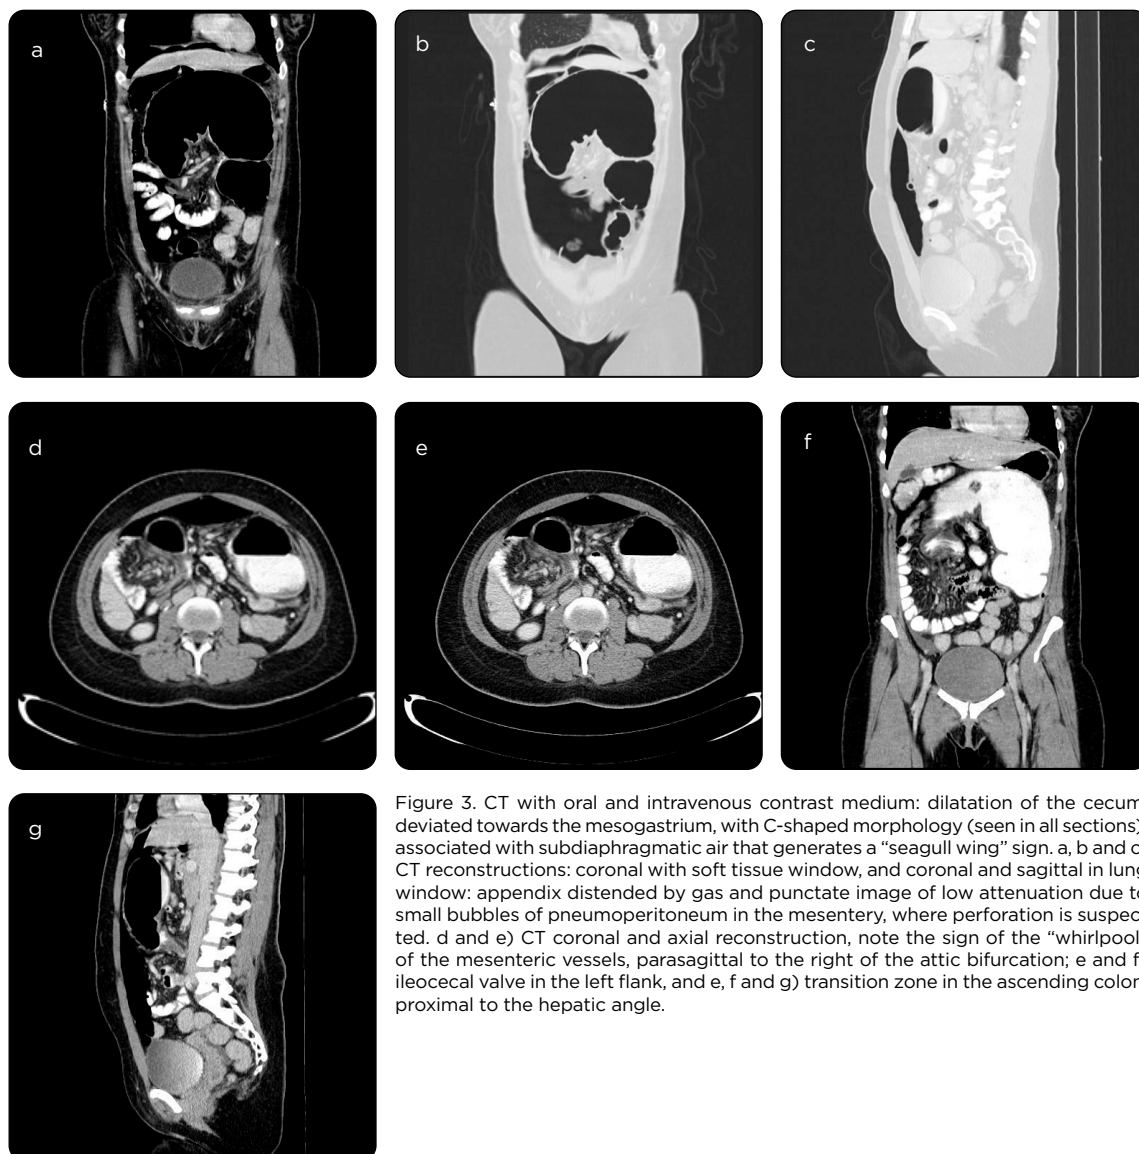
CT with oral and intravenous contrast medium: dilatation of the cecum, deviated towards the mesogastrium, with C-shaped morphology (seen in all sections), associated with subdiaphragmatic air that generates a "seagull wing" sign. a, b and c) CT reconstructions: coronal with soft tissue window, and coronal and sagittal in lung window: appendix distended by gas and punctate image of low attenuation due to small bubbles of pneumoperitoneum in the mesentery, where perforation is suspected. d and e) CT coronal and axial reconstruction, note the sign of the "whirlpool" of the mesenteric vessels, parasagittal to the right of the attic bifurcation; e and f) ileocecal valve in the left flank, and e, f and g) transition zone in the ascending colon, proximal to the hepatic angle.
